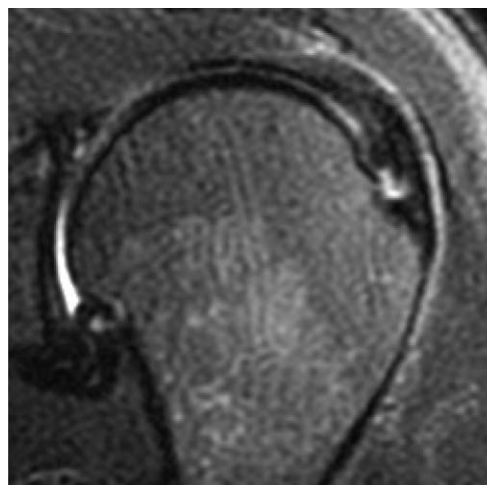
MRI of a partial articular supraspinatus tendon avulsion (PASTA) lesion.
